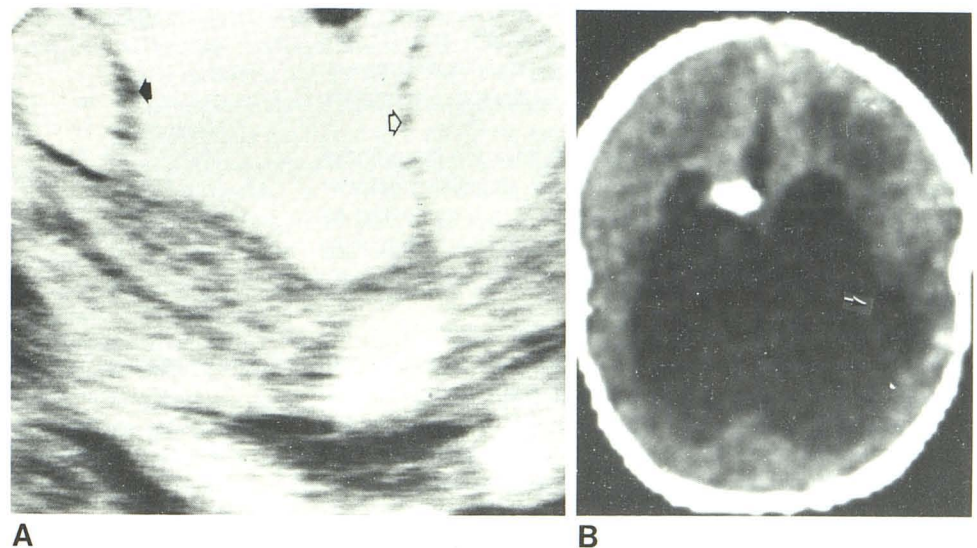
1-week-old infant with *Proteus mirabilis* sepsis. A, Contrast-enhanced scan. Large areas of diminished attenuation believed to be due to cysts, abscesses, or infarcts (arrows). No enhancement is seen. B, Coronal sonogram. Large bifrontal echogenic lesions (arrows) believed to be due to cerebritis. C, Sagittal sonogram 3 days later. Cavitation (arrows) in area of echogenicity in B. Chunks of debris were seen falling from solid part into cystic space during examination. D, 2 weeks later. Increased echogenicity in periphery of abscess cavities (arrow). E, Same day. Enhancement of margins of abscesses (arrows).
